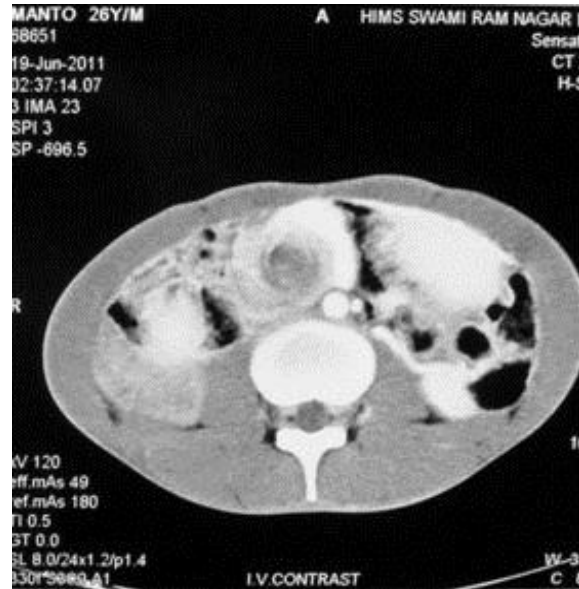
Contrast-enhanced CT scan of abdomen showing "whirlpool sign" suggestive of midgut volvulus.
